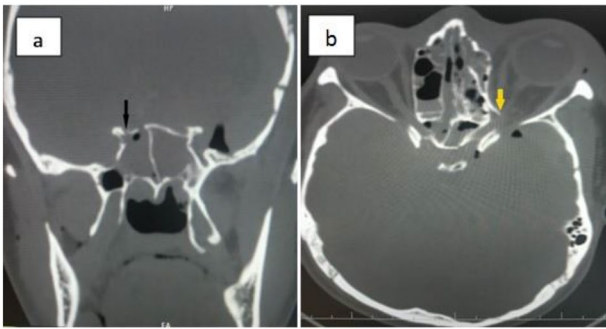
CT scans of patient with bilateral traumatic optic neuropathy: 1a) Black arrow showing a fracture involving right bony optic canal in the sphenoid sinus. 1b) Yellow arrow showing fracture segment impinging on intraorbital portion of the left optic nerve
